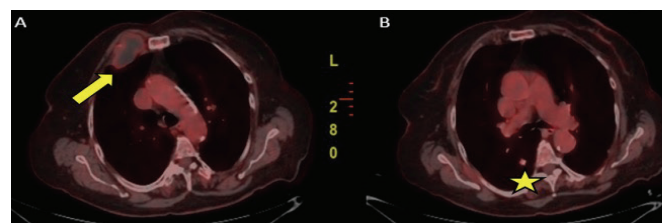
PET-CT images of chest wall hamartoma (a) (arrow) and typical carcinoid tumor (b)(star).
